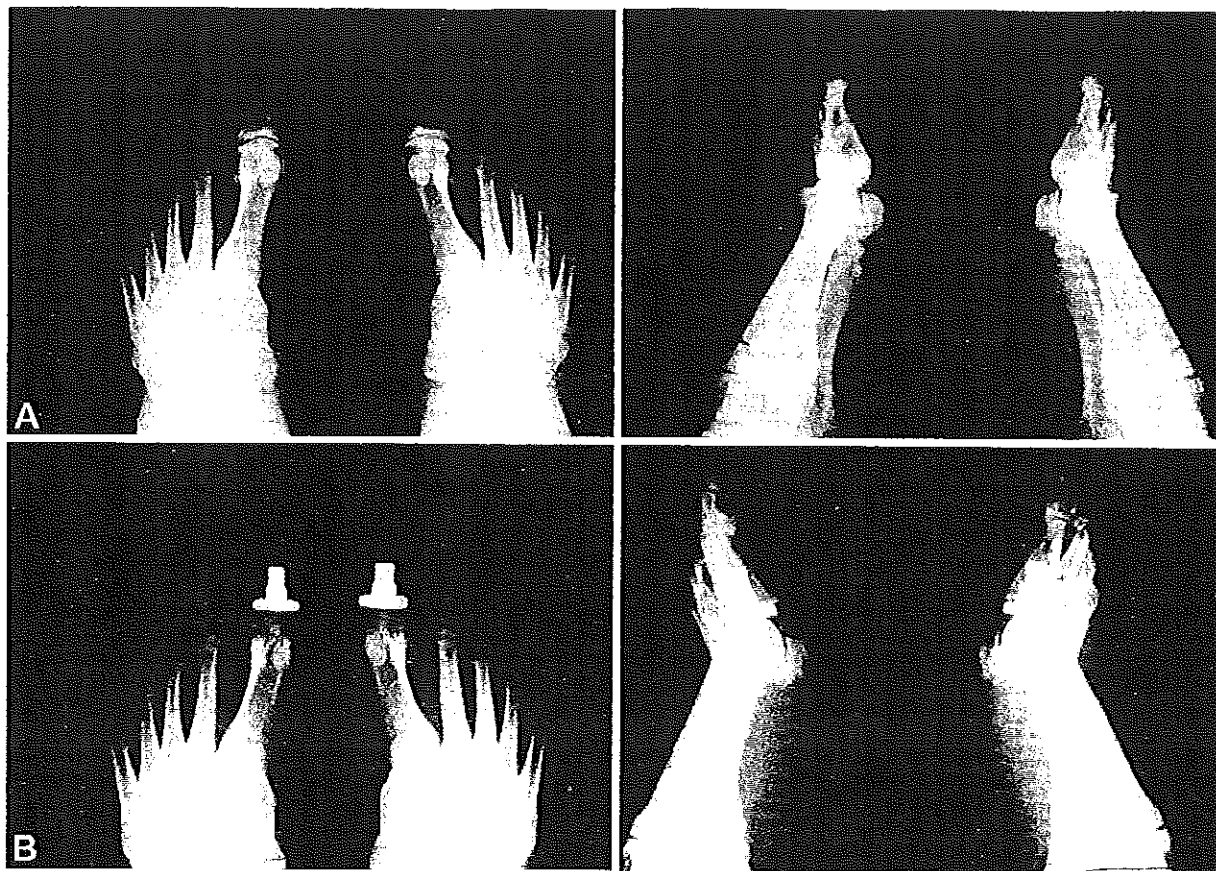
Preoperative (A) and postoperative x-rays (B) 3 years after bilateral arthroplasty for moderately advanced degenerative arthritis in a 36-year-old woman (MB) with severe pain and ambulatory dysfunction. Note the normal position of the sesamoids confirming preservation of the flexor brevis insertions.
